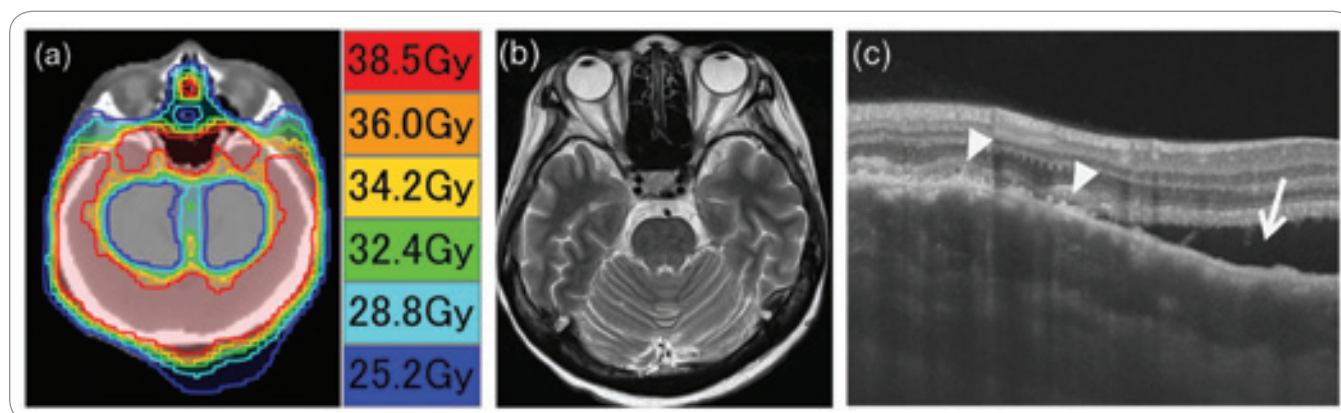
A 54-year-old female with choroidal metastasis of breast cancer in the right eye. (a) Isodose lines of hippocampal avoiding whole brain radiotherapy with corresponding actual radiation dose. The intraorbital proximal 5 mm of both optic nerves were irradiated with a mean dose of 40 Gy in 20 fractions using helical tomotherapy. (b) T2-weighted turbo spin-echo MRI showed no metastatic tumors in the brain or eyes. (c) Optical coherence tomography demonstrated the irregular and undulating anterior surface (arrowheads) with subretinal fluid (arrow).
